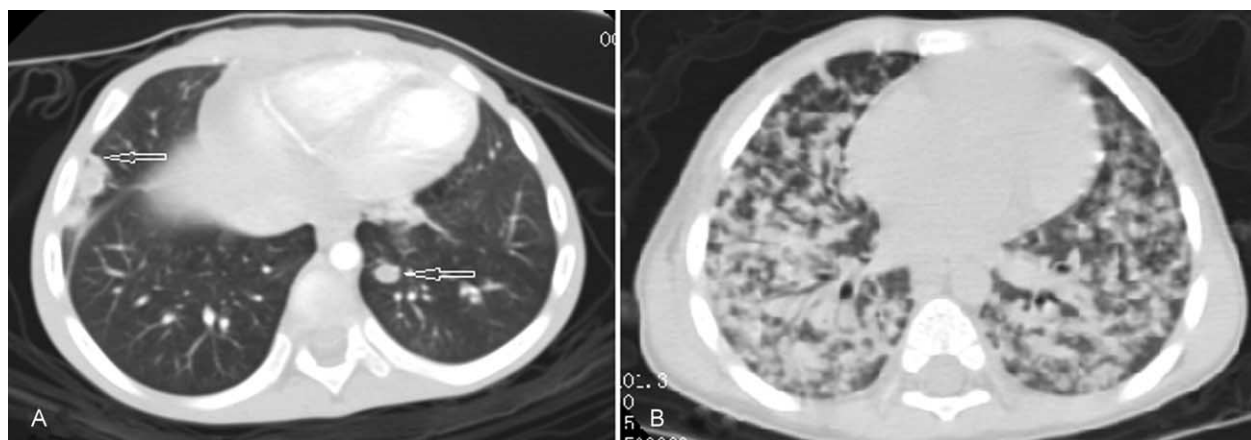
Images from the high-resolution computed tomography of the infants' chests indicated pulmonary involvement, which included (A) the pleural cavity and (B) nodular infiltrates.
